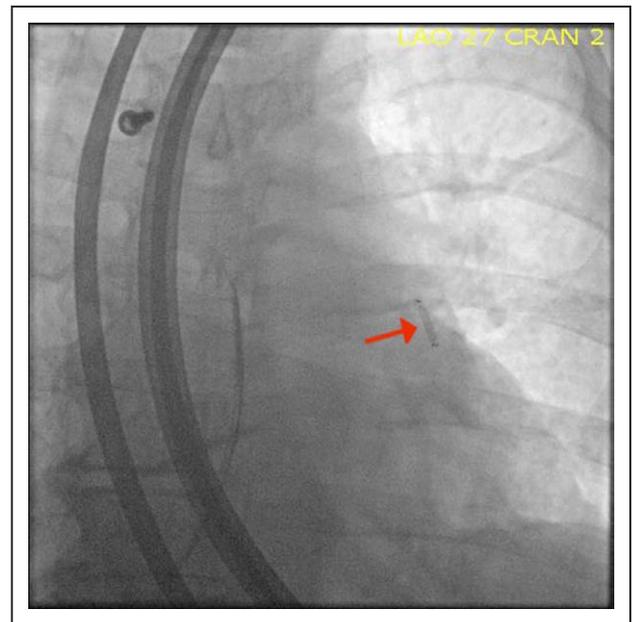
X-ray confirming sensor deployment into the left lung pulmonary artery branch.
